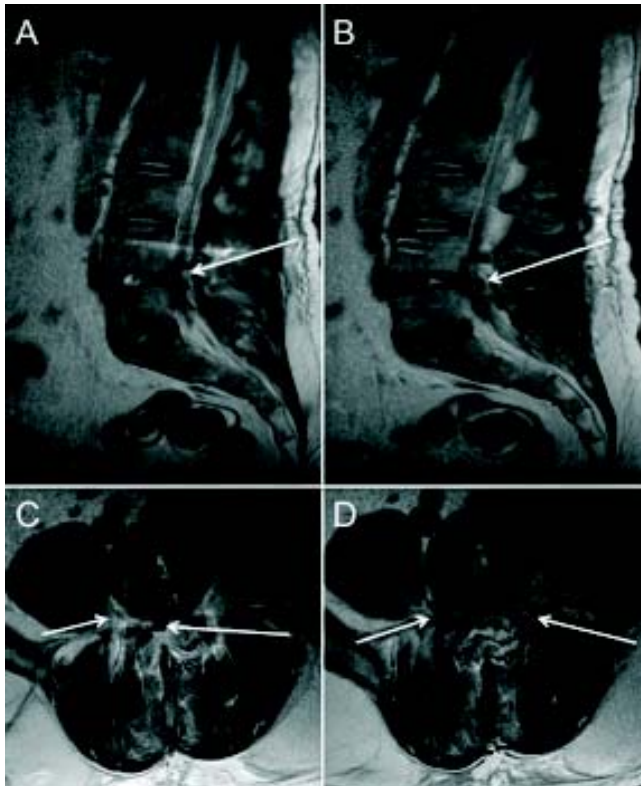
Spine MRI. A and B. Sagittal plane images showing interruption of the *cauda equina* at the L4-L5 level. C and D. Axial plane images depict the stenosis of the spinal canal with severe peridural inflammatory process, it is possible to see the transpedicled metallic rods.
